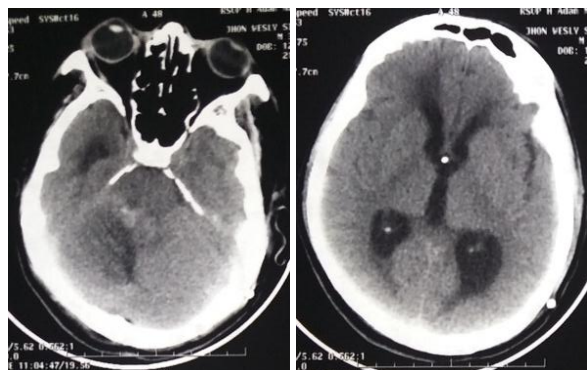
Non Contrast CT Scan of brain after he had been tumor removed and VP Shunt
